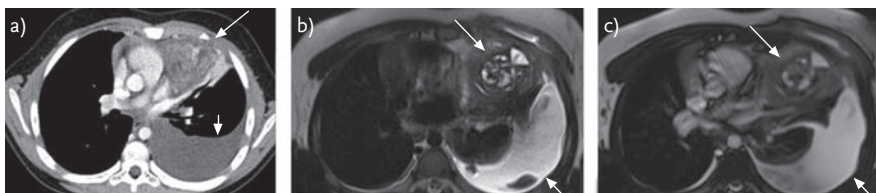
A CT scan, performed after a chest radiograph, in a 10-year-old girl with a history of progressive difficulty in breathing and chest pain. a) A dishomogeneous space-occupying lesion in the mediastinum (arrow) associated with pleural effusion (short arrow) from the upper mediastinal area, in front of the aorta and pulmonary artery, is visible. b, c) MRI confirmed the mediastinal mass causing a compressive effect on pulmonary vessels and parenchyma with almost total collapse of the left lung (arrow) and pleural effusion (short arrow). The signal intensity demonstrated the presence of water intensity cystic spaces with fat-fluid levels (specific for teratoma).
